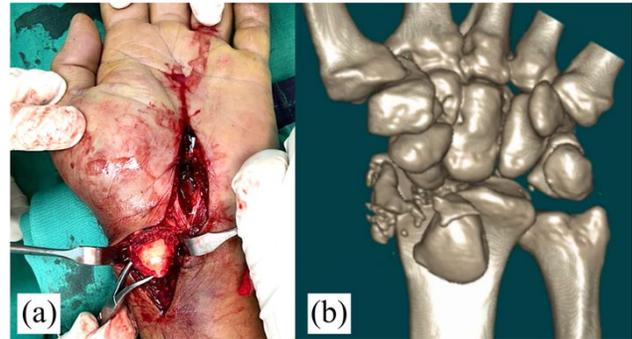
(a) Intraoperative and (b) CT 3D-Reconstruction of Left wrist
